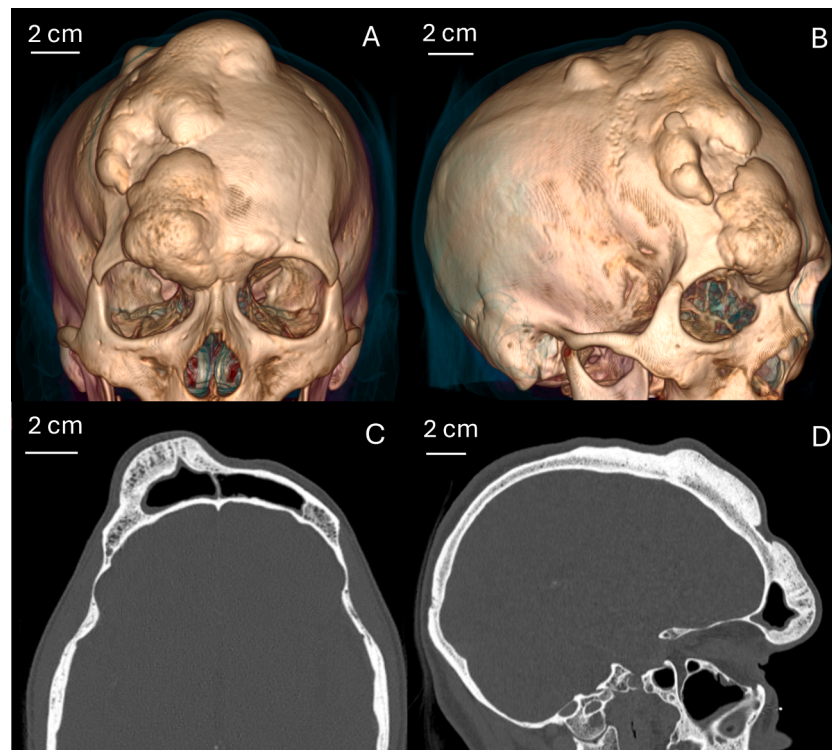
Pre-operative views of the patient. (A) 3D reconstruction front view and (B) side view; (C) and (D) CT-scan axial view and sagittal view respectively.
